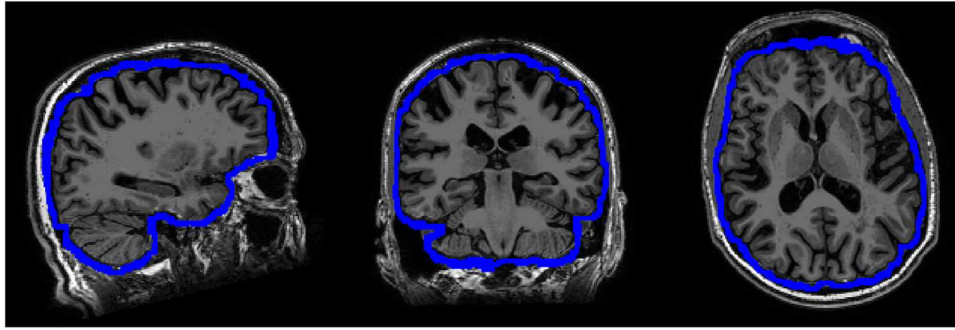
Skull/meningeal mask on a participant's T1-weighted image.
